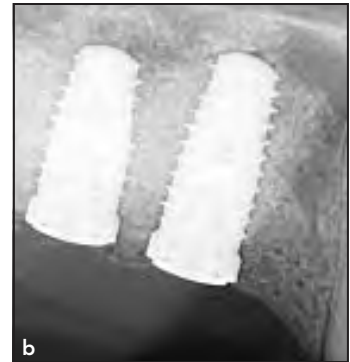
Periapical radiograph at 6 months confirms excellent implant position.
